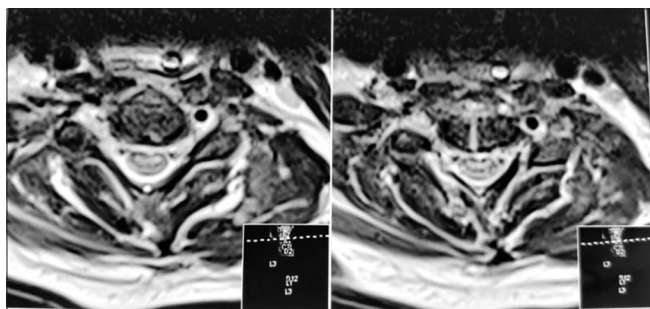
Magnetic resonance imaging T2 weighted axial view demonstrating the fracture with deficient vertebral artery flow void on right side
